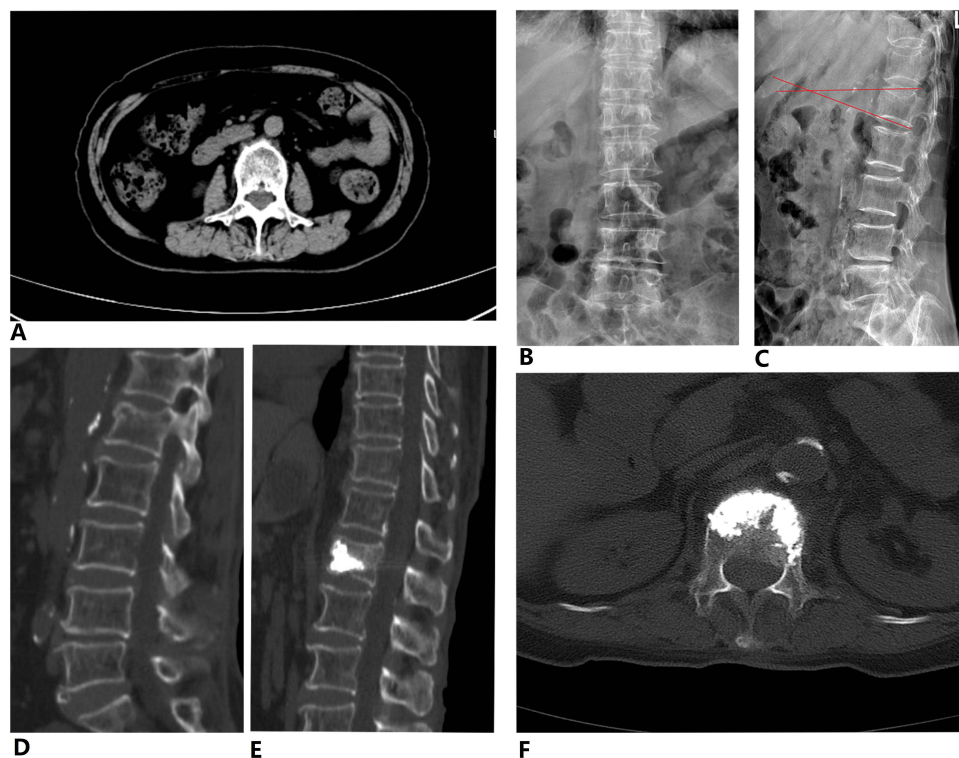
An 84-year OVCF female patient with sarcopenia treated with PKP. (A) the CT scan at the level of third lumbar vertebrae, (B–D) the preoperative X-ray and CT-scan showed L1 compression fracture, and the AH is 66.1%, LKA is 16.4° (Red arrows: Cobb angle between the superior and inferior aspect of the fractured vertebra). (E and F) the post-operative CT scan showed the post-operative AH is 93.1% and LKA is 6.3°.
